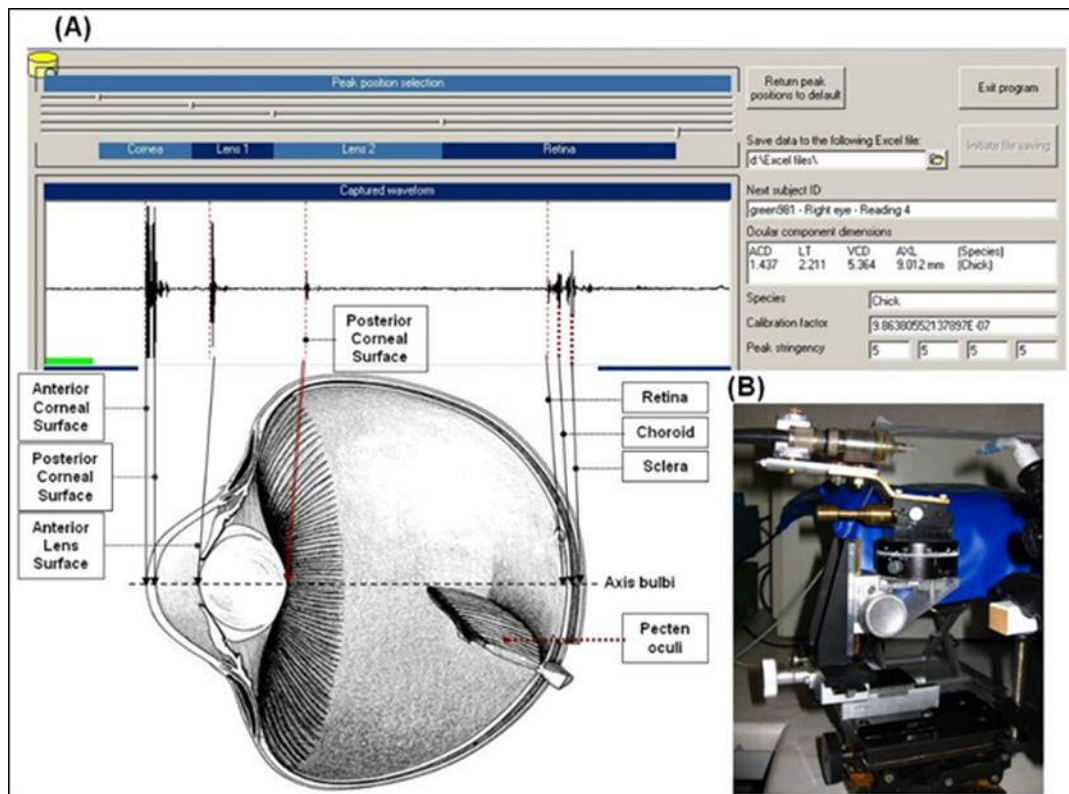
High-frequency A-scan ultrasonography system and holding device (205).
